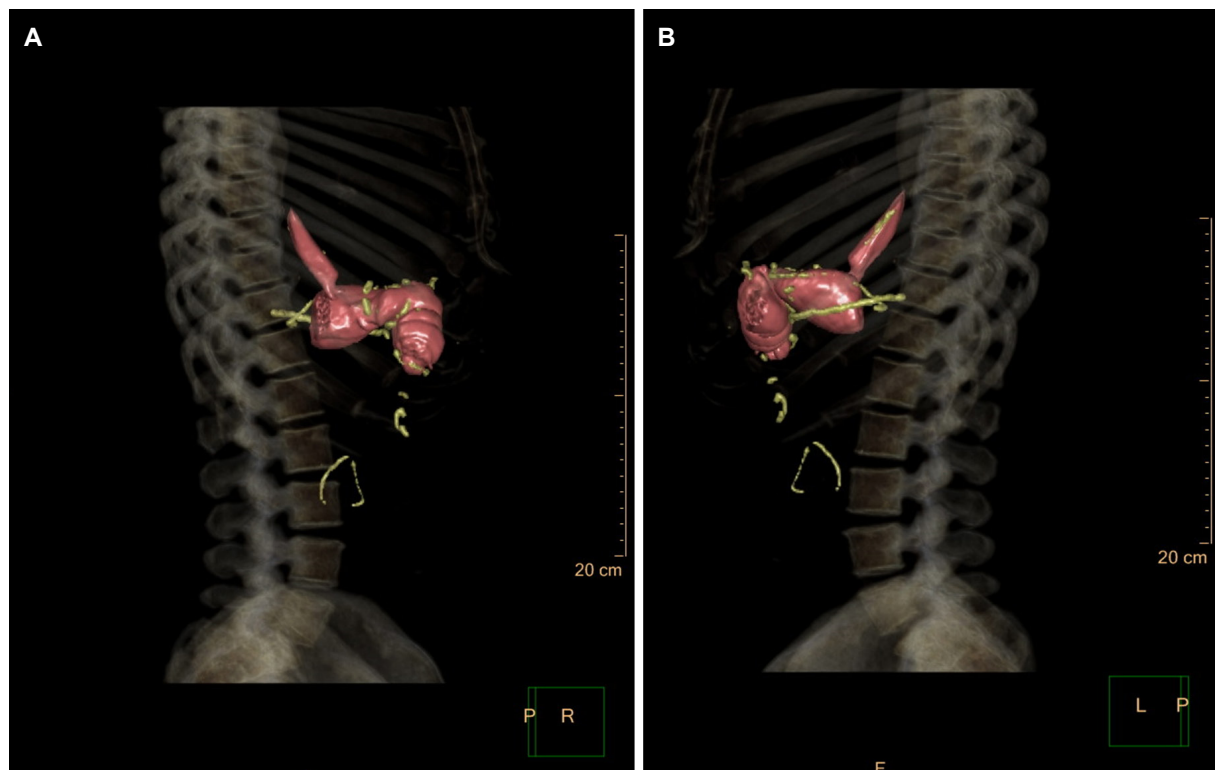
Patient after roux-en-Y gastric bypass. 3D-CT shows the fully distended candy cane in a 360° view
